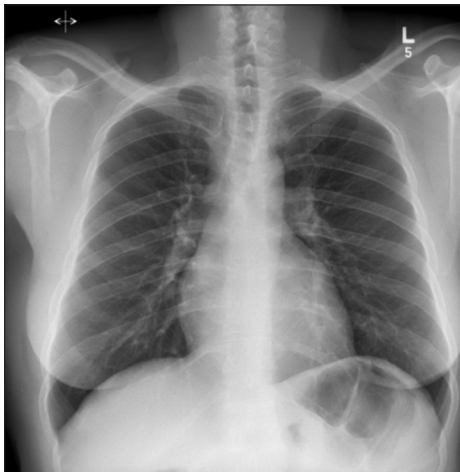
Chest X-ray of patient 2 after 14 months of initiation of direct-acting antivirals showing disappearance of pleural effusion
